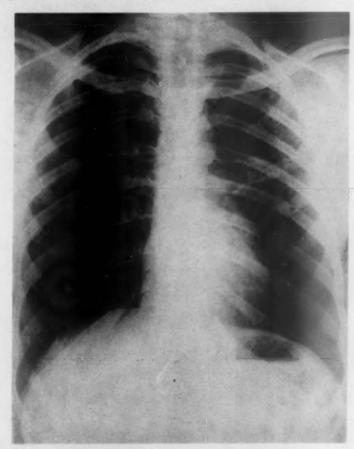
Admission roentgenogram of chest.
